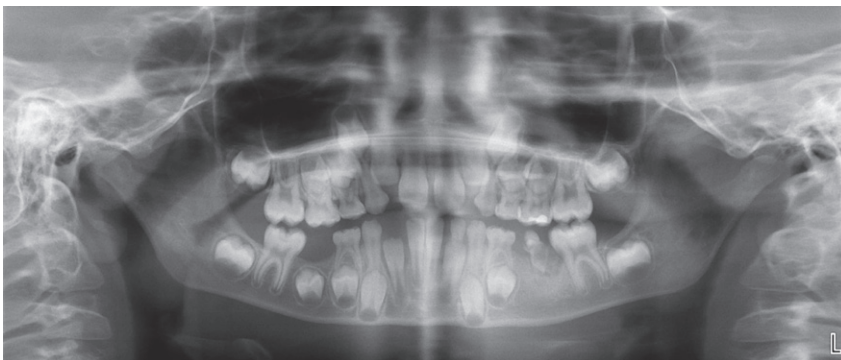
Orthopantomogram taken at consultation prior to the second general anaesthesia for dental treatment at six years and five months-of-age demonstrating premature eruption of tooth 35 with severe enamel hypoplasia and dysmorphic tooth structure, arrested root development and peri-radicular radiolucency
